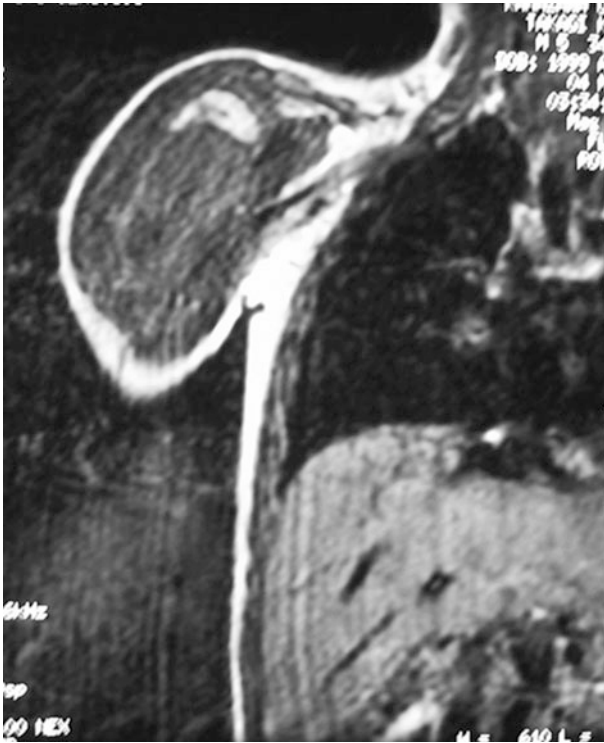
Pre-chemotherapy MRI
